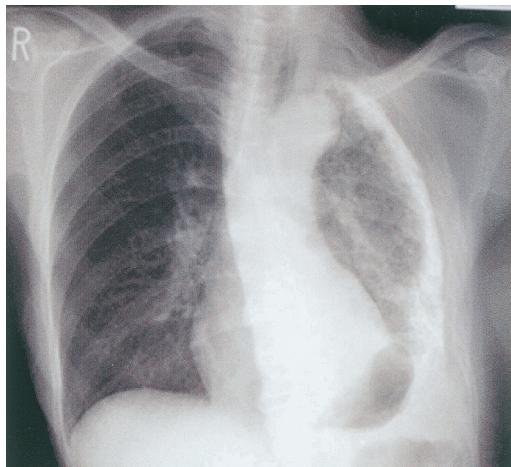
Chest radiograph in May 2004, showing left old.
